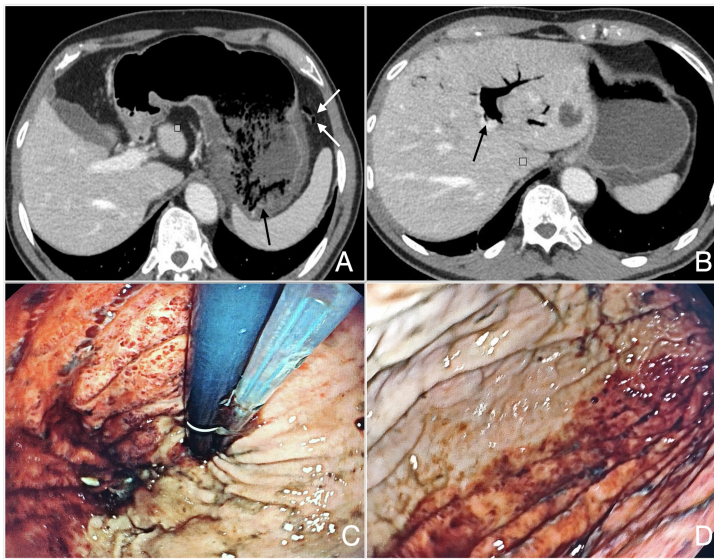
A and B. Computed tomography (CT) image with presence of thickening of the proximal gastric fundus-body, gastric pneumatosis, of the left gastric veins (A) and at the portal level (B). C and D. The esophagogastroduodenoscopy (EGD) showed an erythematous, friable mucosa, with deep erosions on the posterior gastric wall consistent with ischemic injury.
